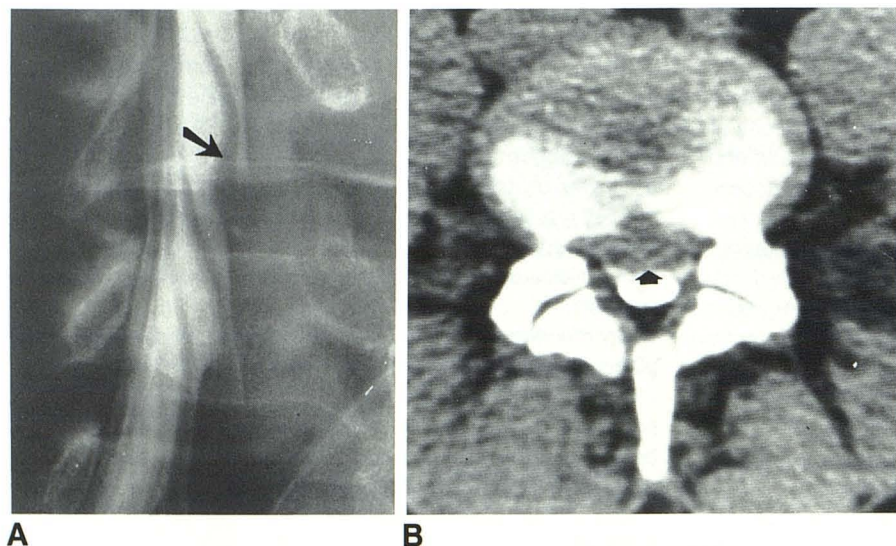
25-year-old man with probable L4–L5 disk herniation. A, Oblique myelogram. Evidence of significant nerve-root compression with amputation of right L5 root sheath and significant flattening of associated nerve root (arrow). B, Metrizamide-enhanced CT scan. Very large central and bilateral disk herniation causing posterior displacement of thecal sac (arrow) and posterolateral splaying of both L5 root sheaths. Clinical response: marked improvement of sciatica.
